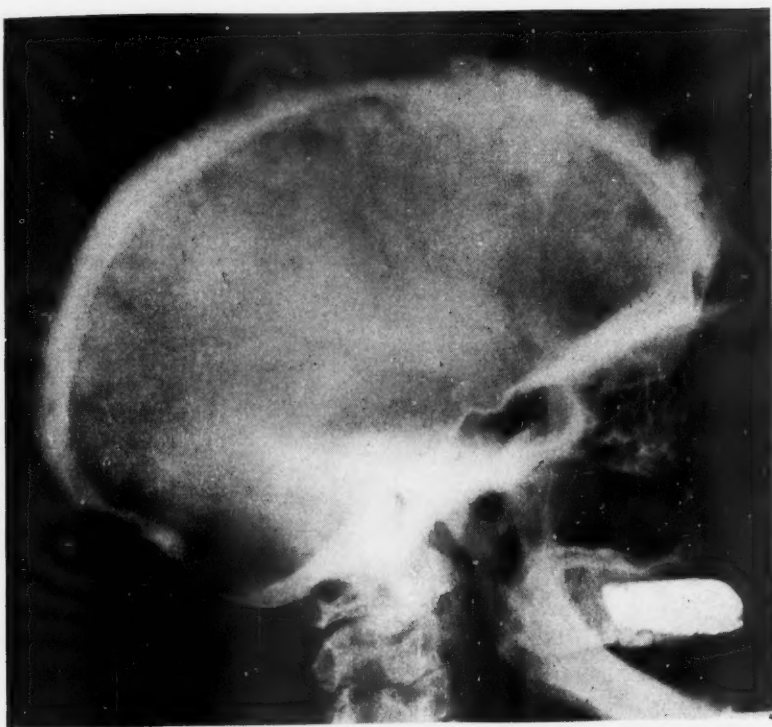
Case 1: Roentgenogram of skull showing osteitis deformans. Note the thick "woolly" appearance of the cranial bones typical of this condition.
